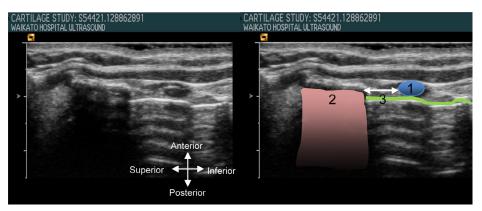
Ultrasound image showing cartilaginous structures of the larynx on longitudinal sagittal view. The image on the right is a numbered version of the left to highlight anatomical structures. (1) Cricoid cartilage, (2) lower edge thyroid cartilage, (3) tracheal lumen (line). *Arrow*: anterior cricothyroid space. There is a centimeter scale bar on the left of each image (Source: Author).
